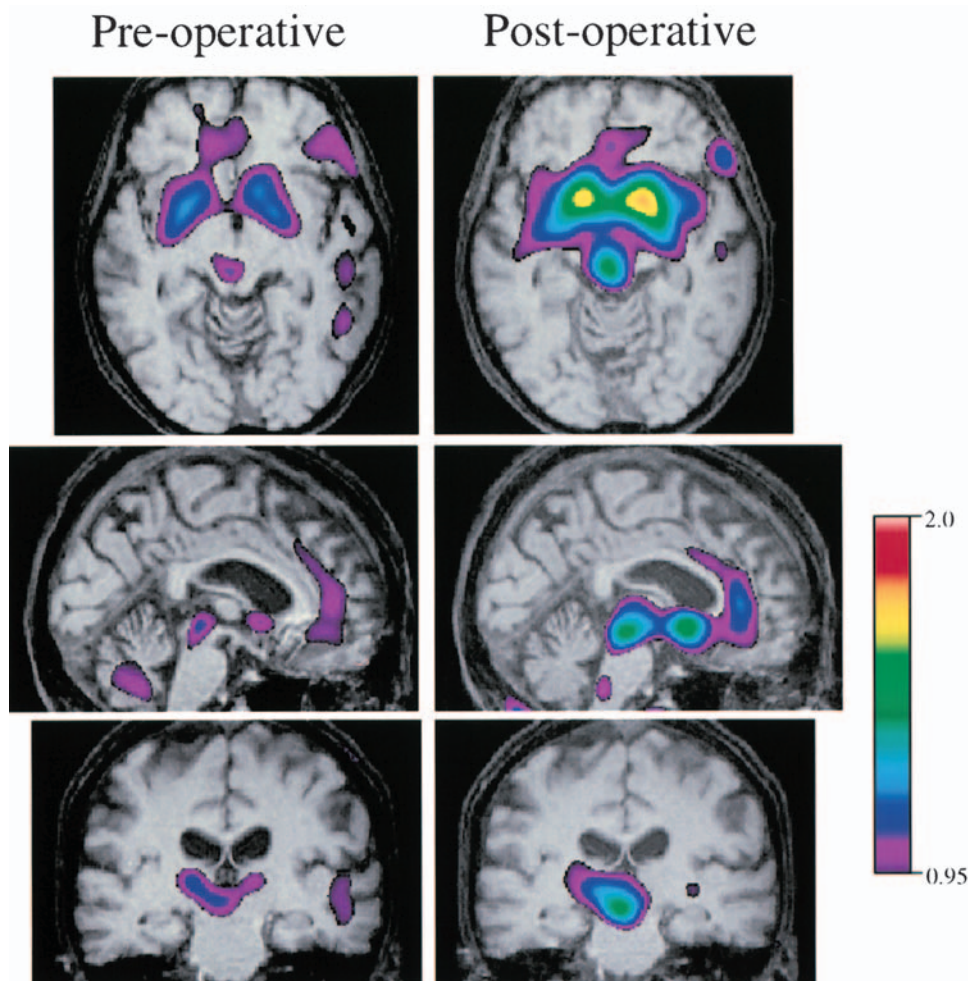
Preoperative and postoperative fluorodopa PET scans obtained in a patient with PD (Case 3) who received simultaneous intrastriatal and intranigral fetal VM grafts. These images consist of parametric maps of fluorodopa  $K_i$ , transformed into stereotactic space and overlaid on the patient's MR image (also in stereotactic space). The parametric maps were smoothed using an 8-mm gaussian filter. The axial, coronal, and sagittal sections demonstrate an increase in  $K_i$  in the midbrain and putamen bilaterally, likely resulting from surviving grafted dopamine neurons.
